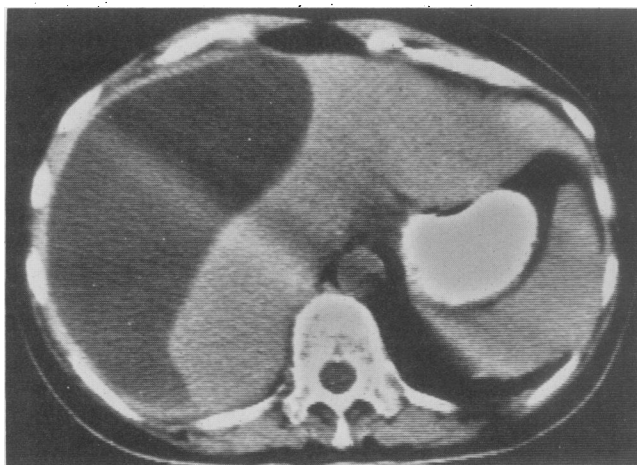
A computed tomographic scan of the upper abdomen shows a large cystic mass contiguous with the right lobe of the liver.
